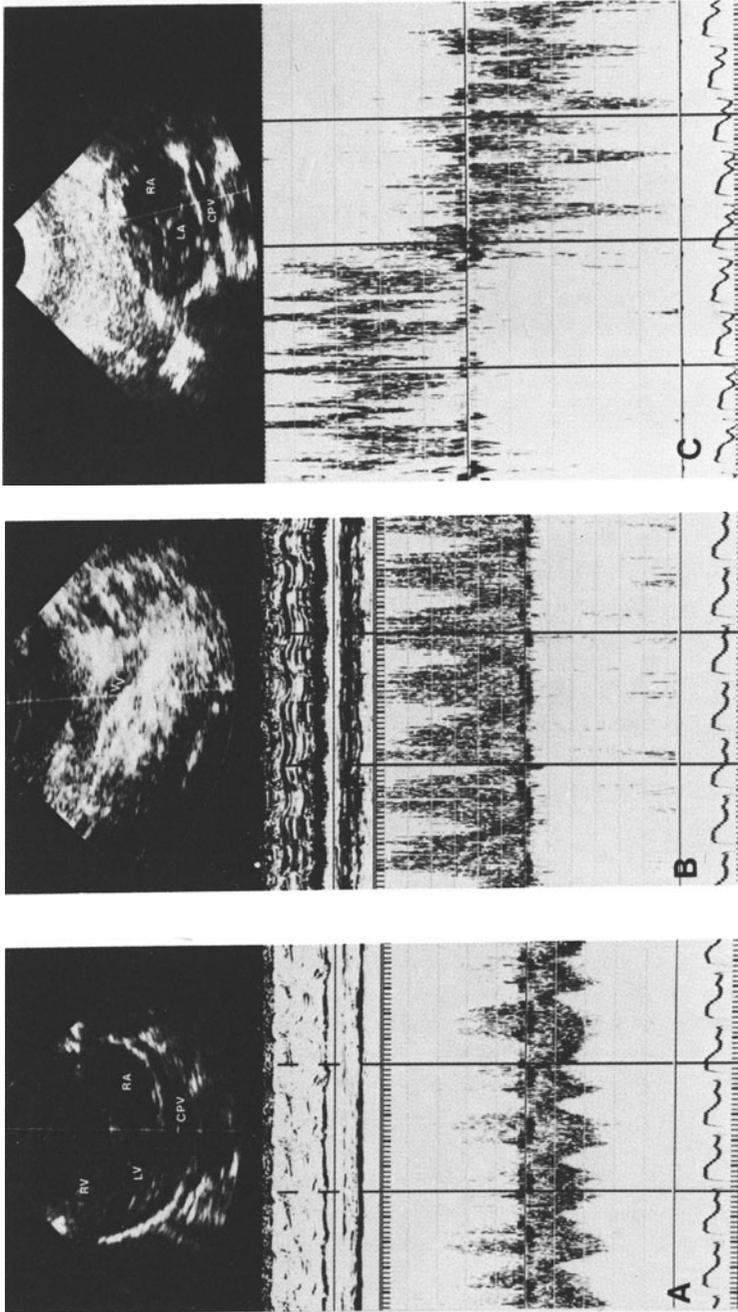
Two-dimensional echo views and pD tracings of a neonate with supracardiac TAPVD. (A) The typical posterior direction of the blood flow in the common pulmonary vein (CPV); i.e., away from the transducer. In the vertical view (VV), which connects the CPV with the innominate vein, the flow has a characteristic inferosuperior direction (subcostal view, B). (C) The sample volume is moved from the RV inflow to the foramen ovale. The left side of the Doppler tracing shows the anteriorly directed blood flow towards the RV; the right side, the posteriorly directed flow through the foramen ovale, which corresponds with the obligatory R-L shunt.
